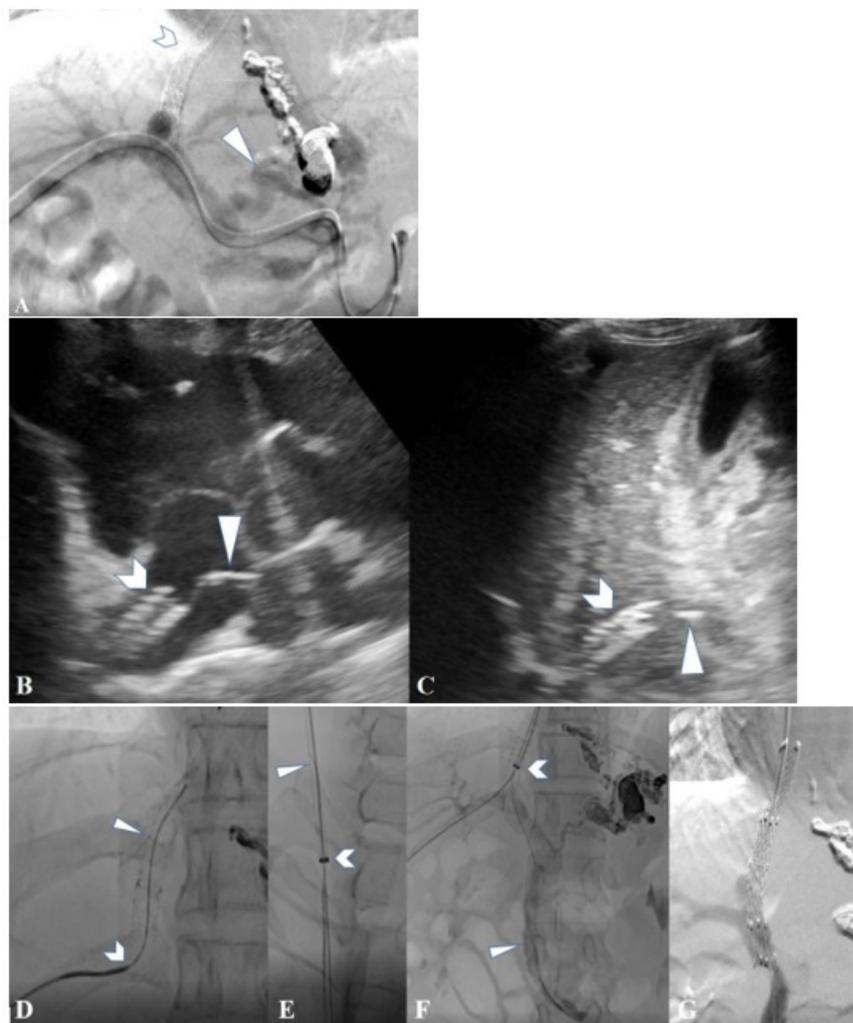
Entry of dysfunction shunt and revision. (A) Initial percutaneous splenoportography shows the stent displacement and the shunt occlusion (white arrowhead) with recurrent gastric varices (white triangle). (B) Sonogram shows stent displacement (white arrowhead) into the right ventricle, and shunt entry was attempted from the transjugular approach under ultrasound (US) guidance with a VER catheter (white triangle). (C) Sonogram shows attempt of transhepatic access into the shunt under US guidance with a VER catheter (white triangle). (D) Transhepatic guidewire (white triangle) was maneuvered through the shunt (white arrowhead) into the right ventricle. (E) Transhepatic guidewire (white triangle) was maneuvered through the transjugular sheath (white arrowhead), thus creating transhepatic-transjugular guidewire. (F) Transjugular sheath (white arrowhead) was advanced into the shunt over the transhepatic-transjugular guidewire, and hydrophilic guidewire was maneuvered through transjugular sheath into superior mesenteric vein, followed by mesentericoportography (white triangle). (G) Fluoroscopic image of the shunt after deployment of metal stents across tract between hepatic and portal vein from transjugular approach.
